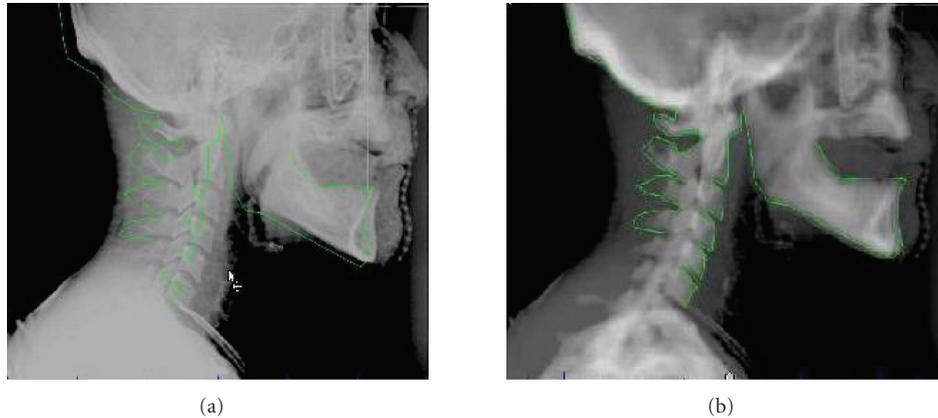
Example of 2D kV image used for verification of patient positioning. A 2D projection was created from the planning CT, and the bony anatomy was contoured (solid line). This image was then overlapped with a kV image taken immediately prior to treatment delivery. The overlay is shown before (a) and after (b) adjustments are made.
